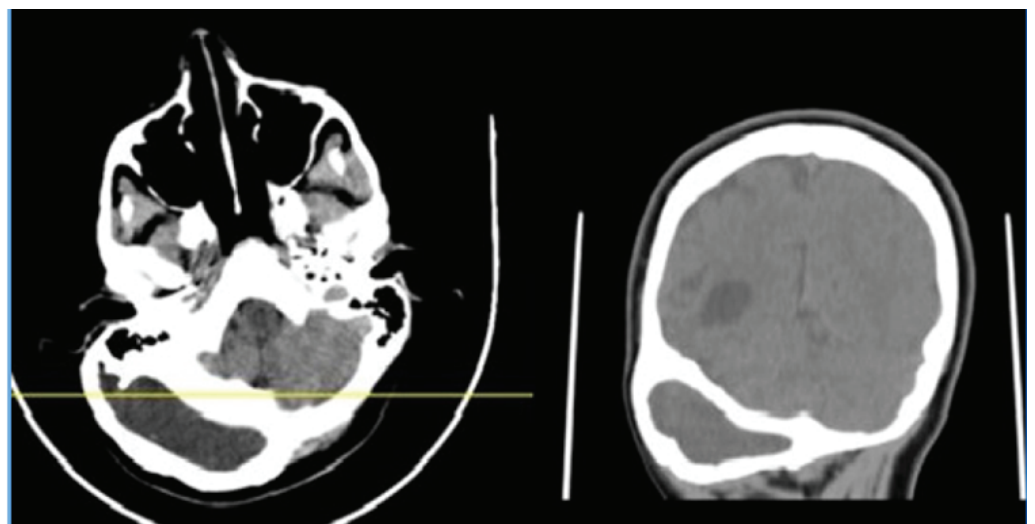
Cranial CT, cystic lesion located in right occipital bone
